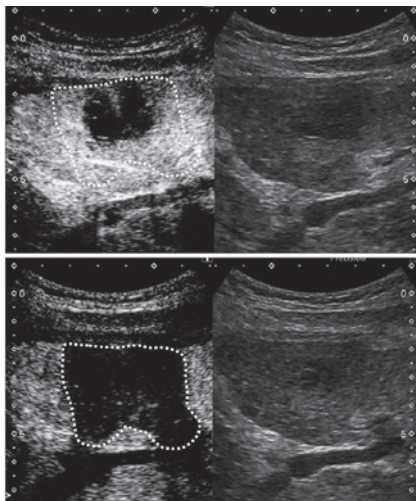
Contrast ultrasound after IRE. In the vascular phase (upper) only the tumor area indicates a perfusion defect. However, Kupffer phase imaging (lower) indicates that the contrast defect area is much wider than that in the vascular phase. B-mode imaging (right) informs us nothing regarding the ablation area.
